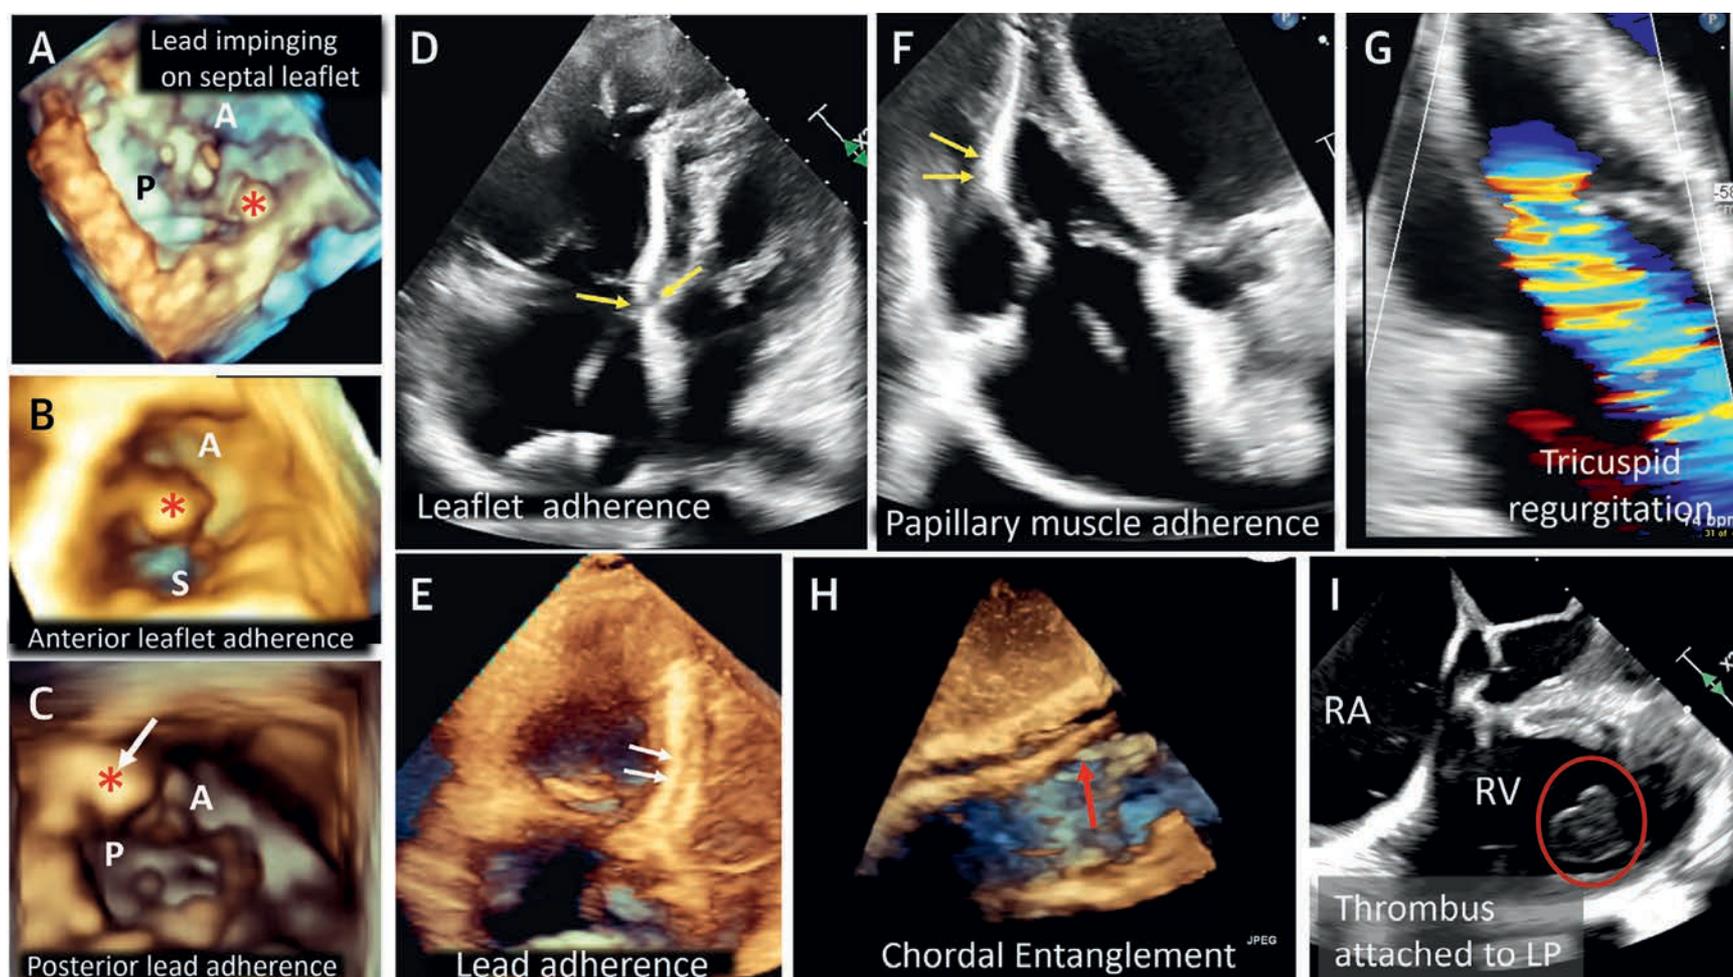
Echocardiographic Diagnosis of the Cause of Cardiac Implantable Electronic Device Lead-Induced Tricuspid Regurgitation.
